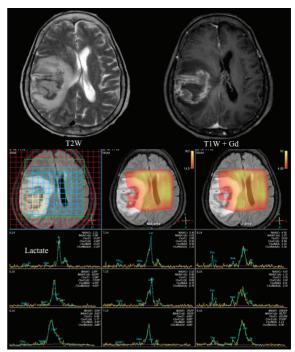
MRI of the brain of the first patient after 1 week of ceftriaxone and clindamycin (T2W, T1W with gadolinium) showing a high SI on T2W, iso-SI on T1W with peripheral rim enhancement in the right frontotemporoparietal region and an increase in the degree of midline shift with right uncal herniation (A). Presence of lactate peak with decreased choline, creatine, and NAA on MRS (B).
